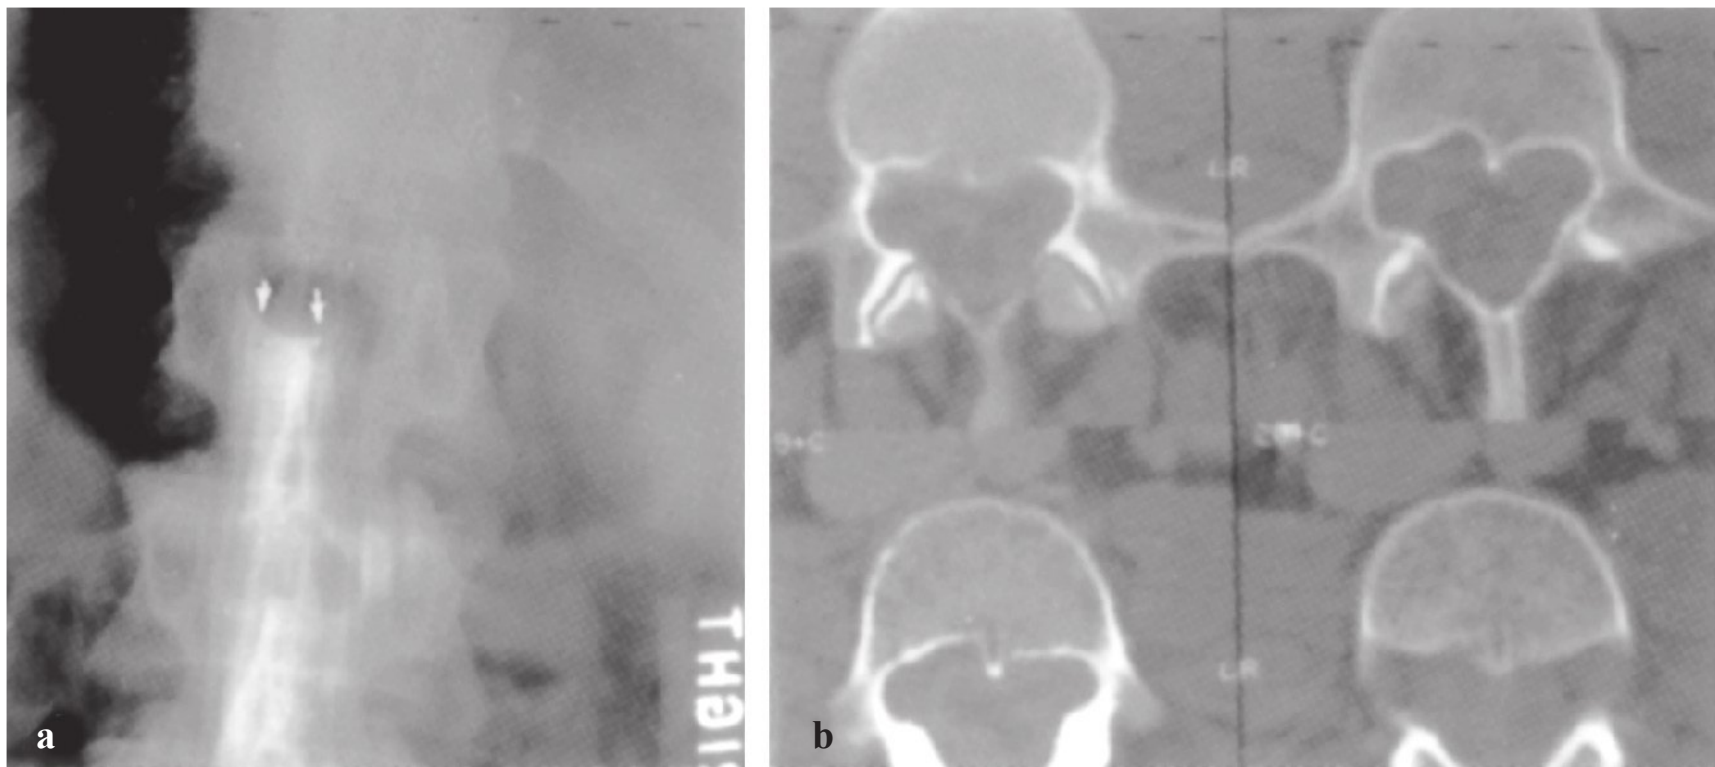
Intradural neurofibroma. (a) Anteroposterior myelography showing a myelographic block at L1 due to a neurofibroma. The myelographic block is smooth and meniscal in shape (arrows) due to the intradural adhesions, whereas extradural lesions produce a ragged margin. (b) Computed tomographic scans showing erosion of the vertebral body and pedicle due to expansion of intradural neurofibromas.
